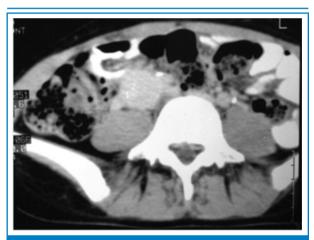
Contrast CT pelvis showing homogenous enhancement
